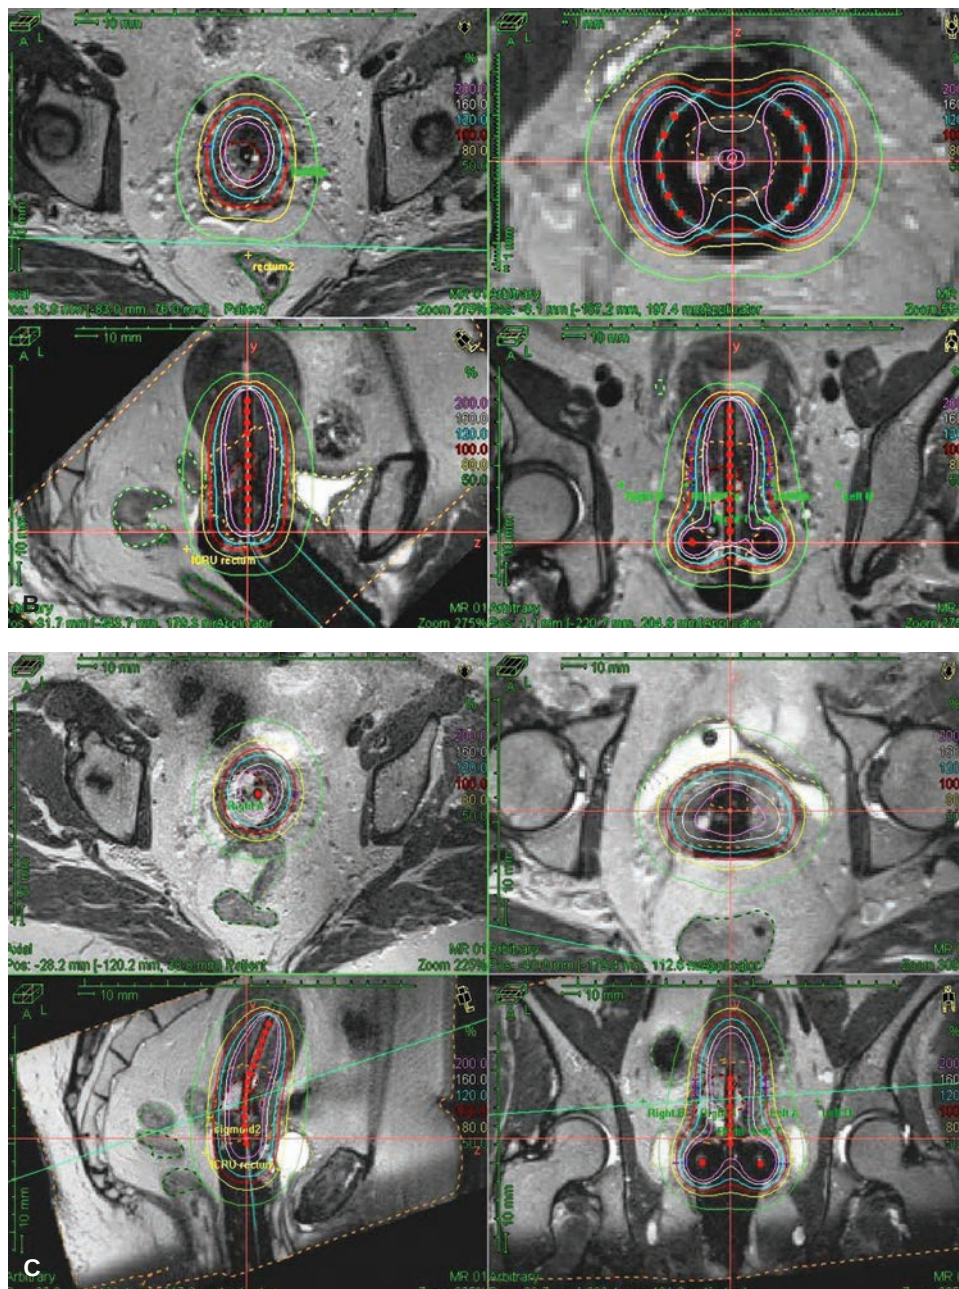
B, C: MRI of the pelvis with an MRI/CT compatible applicator ring B: and ovoids C: in place. Note the associated dose distribution relative to visible tumor within the cervix and the bladder, rectum and sigmoid.
